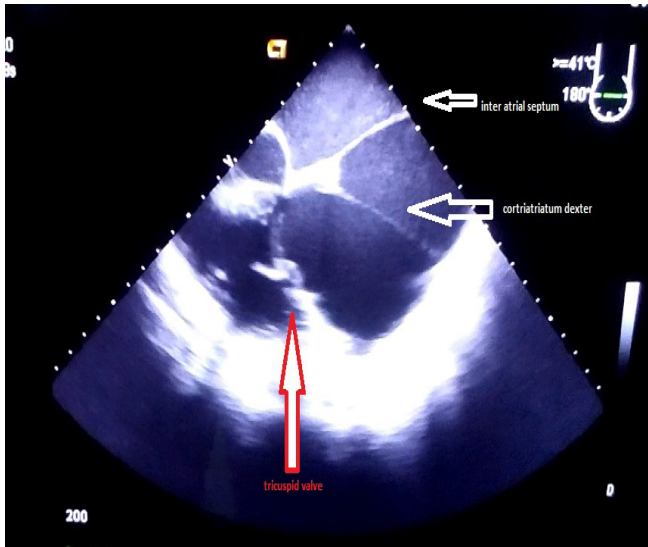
2D transoesophageal echocardiography showing presence of a membrane separating the right atrium into two parts
